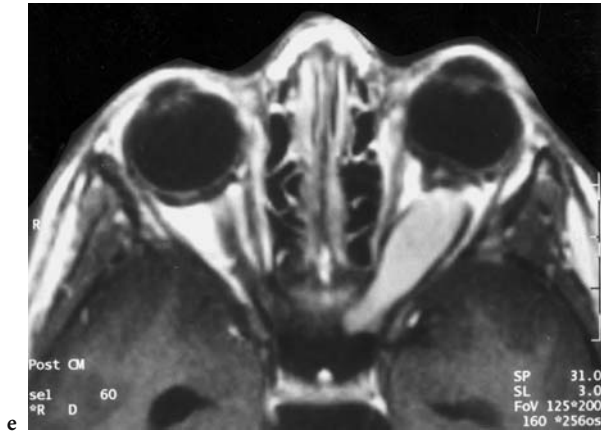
A 6-year-old boy with known NF1 and left-sided papilledema, detected on routine control of juvenile hypertonus. Diagnosis: left optic nerve glioma. a Ultrasound, demonstrating the thickening of the posterior part of the optic nerve (courtesy of Prof. Schumacher, Kinderklinik Mainz). Axial CT: b In the absence of left eye proptosis, a considerable widening of the left optic nerve sheath complex is seen. c Bone window at the level of the optic canal, showing its widening. MRI: d Axial T2-weighted view where a small hyperintense rim is seen that corresponds to the remaining arachnoid space around the optic nerve tumor, occupying the posterior two-thirds of the orbit (compare with a). e Axial, T1-weighted, contrast-enhanced view with enhancement of the tumor and demonstration of the remaining, slightly enlarged subarachnoid space (hypointensity). f Parasagittal, T1-weighted, contrast-enhanced view, where the extension of the glioma into the optic canal is seen (*arrow*). g Coronal T2-weighted view clearly showing the different diameters of the optic nerve. h Axial T2-weighted FLAIR view of the brain, demonstrating bilateral “hamartoma” of the basal ganglia region. Recurrence is suspected based on progressing proptosis of the left eye 6 months after initial surgery (prechiasmatal amputation of the left optic nerve): i axial, T1-weighted, contrast-enhanced (FS) view, showing the pronounced proptosis and nearly unaffected left optic nerve glioma. k Coronal T1-weighted native view, demonstrating the extension of tumor into the defect of the roof of the optic canal, opened by previous surgery
